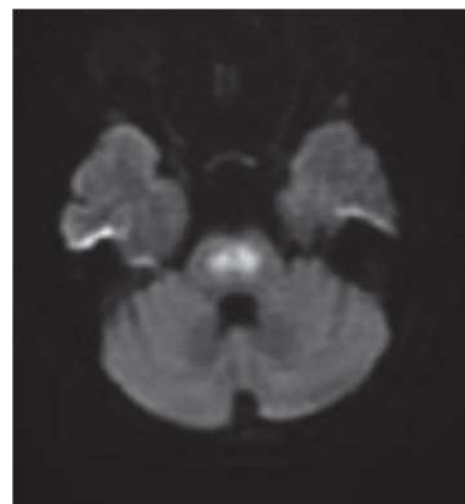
Axial DWI image showing restricted diffusion in pons
